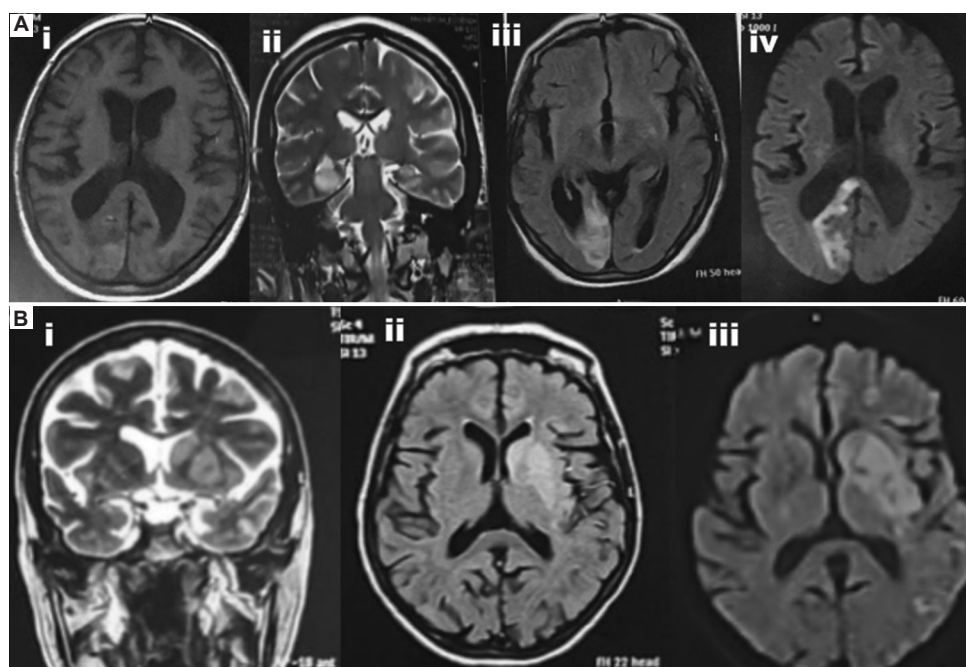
Magnetic resonance imaging (MRI) of patients with uremia and cerebrovascular stroke. (A) MRI-brain axial and coronal views) of a 62-year-old man. He had hypertension for 10 years and uremia at the age of 55 years. He developed a visual field defect. He had a lesion in the right occipital lobe. The lesion is hypointense in (i) T1WI and hyperintense in (ii) T2WI, (iii) FLAIR, and (iv) DWI (i.e., ischemic lesion). (B) MRI-brain (coronal and axial views) of a 60-year-old male (age at presentation). He had diabetes for 8 years, developed uremia at the age of 55 years, and is on regular hemodialysis. He developed right-sided rest tremors and rigidity (parkinsonism) during the period of the study. He had MRI lesions in the left caudate and lentiform nuclei. Lesions are hypointense in T1WI and hyperintense in (i) T2WI, (ii) FLAIR, and (iii) DWI (i.e., ischemic lesions).
